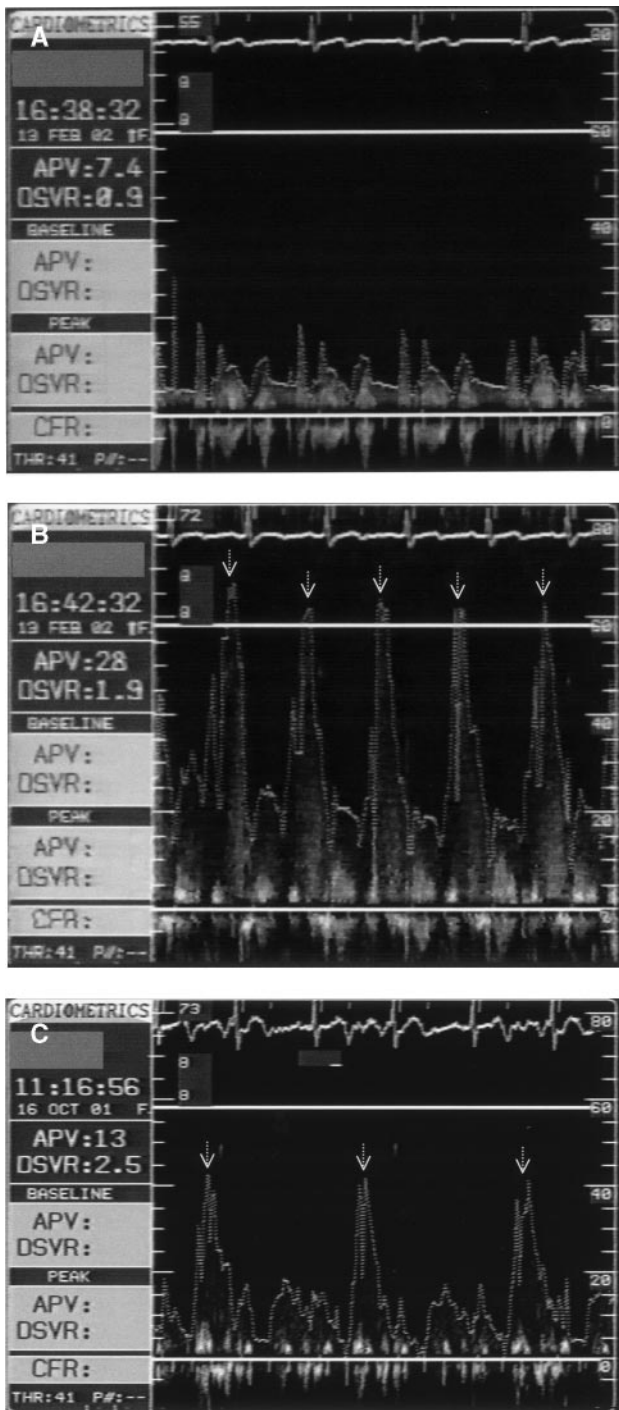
Representative Doppler flow velocities obtained with the FloWire in the right coronary artery at baseline (A), during EECF with 1:1 counterpulsation (B), and from another patient during EECF with 1:2 counterpulsation (C). The APV and DSVR are calculated by the FloMap for each tracing. Diastolic augmentation is identified by the dashed arrows.
